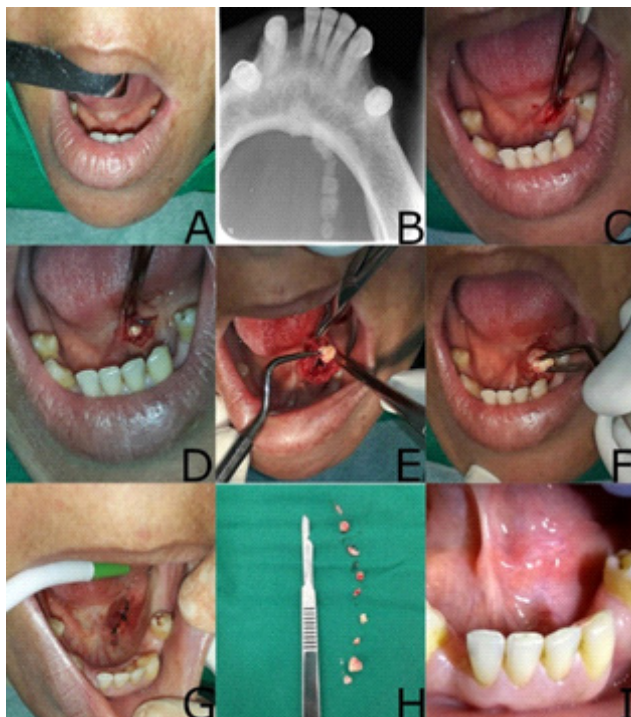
A. Aspect of the lesion in the preoperative period: an intra mucosal volume increase similar in color to that of the Oral mucosa; B. Occlusal radiograph showing multiple calculi; C-F. Initial incision, division of tissues and removal of stones; G. Suture; H. 9 Removed Calculi with varying sizes; I. Appearance sublingual after 15 days.
